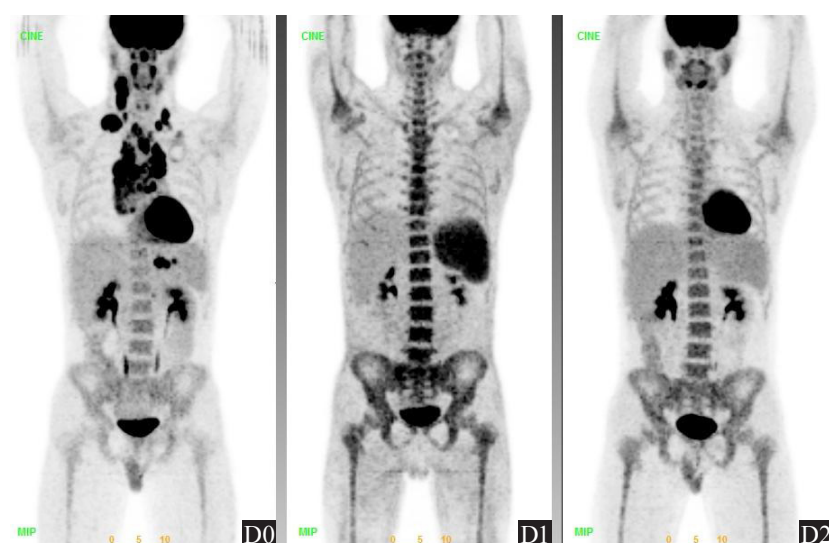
Anterior view of maximum intensity projection (MIP) ^{18}F -FDG PET images of initial staging scan (D0), mid-treatment scan (D1) and post-treatment scan (D2) of a 15 years old white male. One lesion from each of the following: right cervical, right supraclavicular, right mediastinum, left mediastinum and gastrosplenic region, were included for analysis. The bone marrow and spleen are excluded from the analysis.
